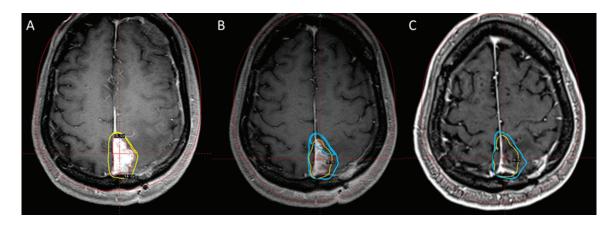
A) T1 Axial MRI on day of first stage radiosurgery showing a parasagittal metastasis. 15 Gy was prescribed to the 50% isodose line (yellow line). B) T1 Axial MRI on day of second stage radiosurgery showing tumor regression. Blue line represents prior treatment prescription. A second dose of 15 Gy was prescribed to the 50% isodose line, this time to a smaller volume. C) T1 Axial MRI at 6 month follow-up showing near complete regression of the original tumor. First stage (blue) and second stage (yellow) prescription isodose lines are super-imposed.
